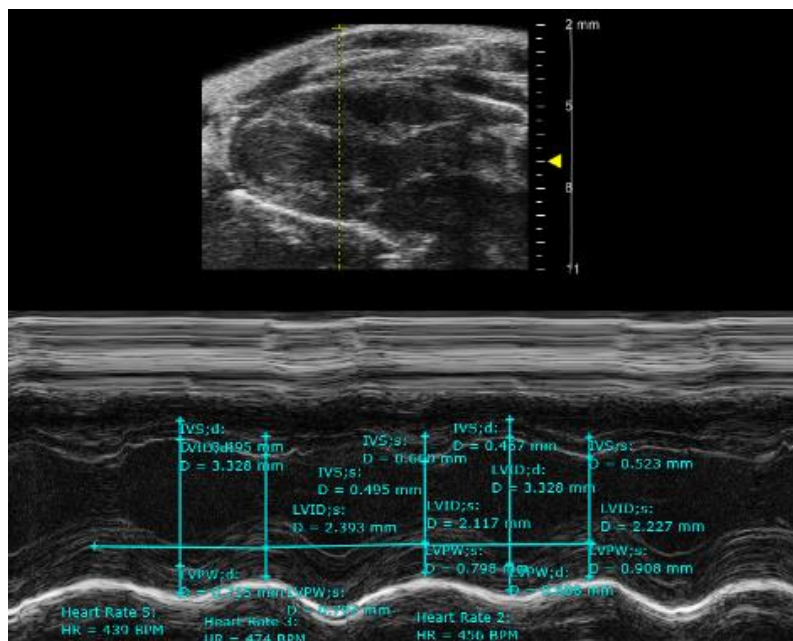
M-mode of Parasternal long axis view, at papillary muscle level.
